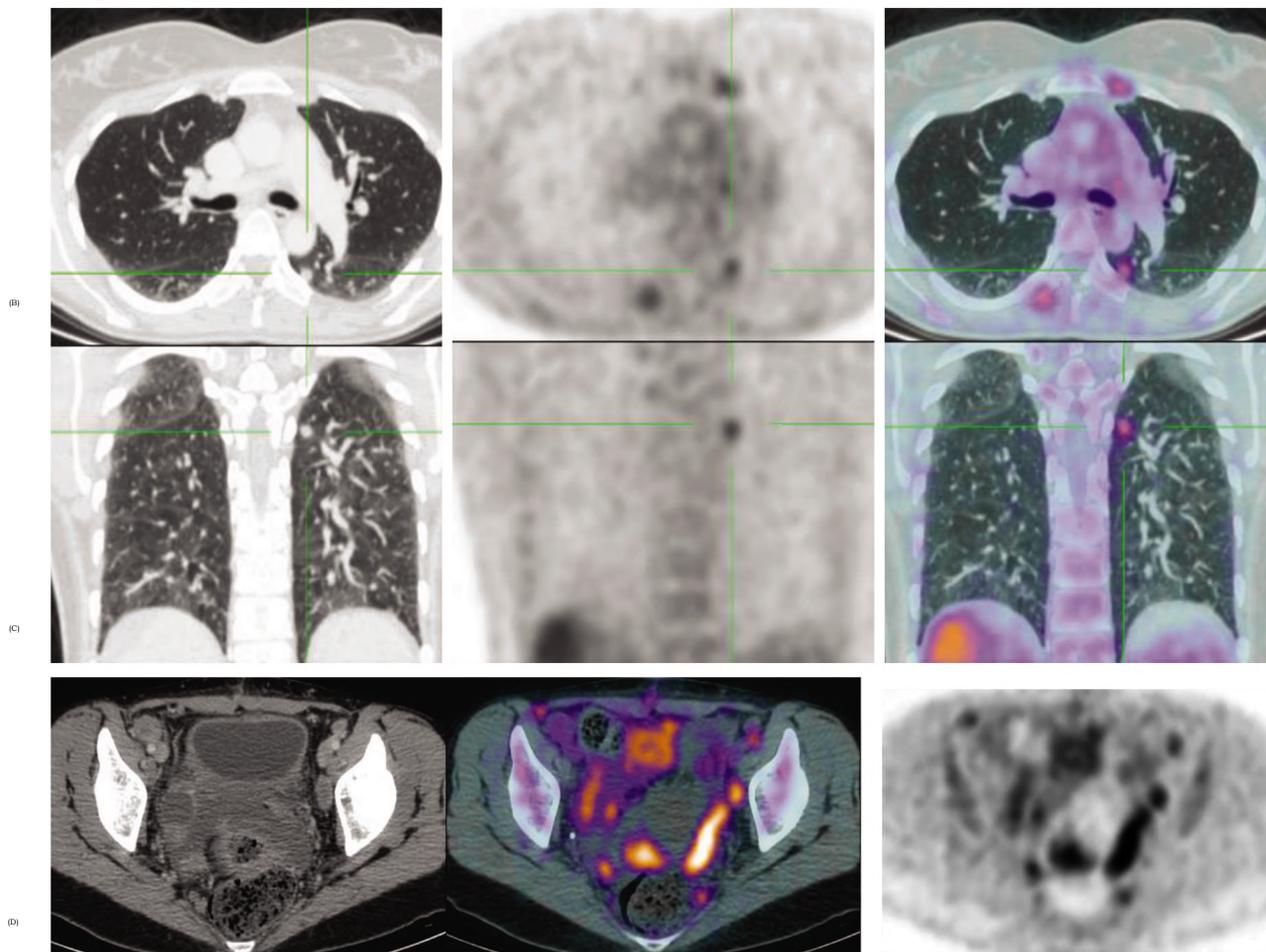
A 63-years-old female patient having an old history of treated ovarian cancer 5years ago and a recent CT was done showed a SPN.(A) A whole body combined PET scan, (B) a series of contrast enhanced axial CT, PET & combined PET/CT images, (C) a series of contrast enhanced coronal CT, PET & combined PET/CT images, (D) axial CT, PET & combined PET/CT images. The whole body PET/CT study was done & showed increased FDG uptake by that SPN in the apical segment of left lower lung lobe with SUVmax 3.5 and measures 7.0 mm. Additionally, multiple mediastinal, abdominal and pelvic lymphadenopathy with pelvic peritoneal sheets of increased uptake were noted, suggesting local residue or recurrence of the ovarian neoplasm with metastatic spread. Therefore, that SPN was considered as a metastatic nodule.
